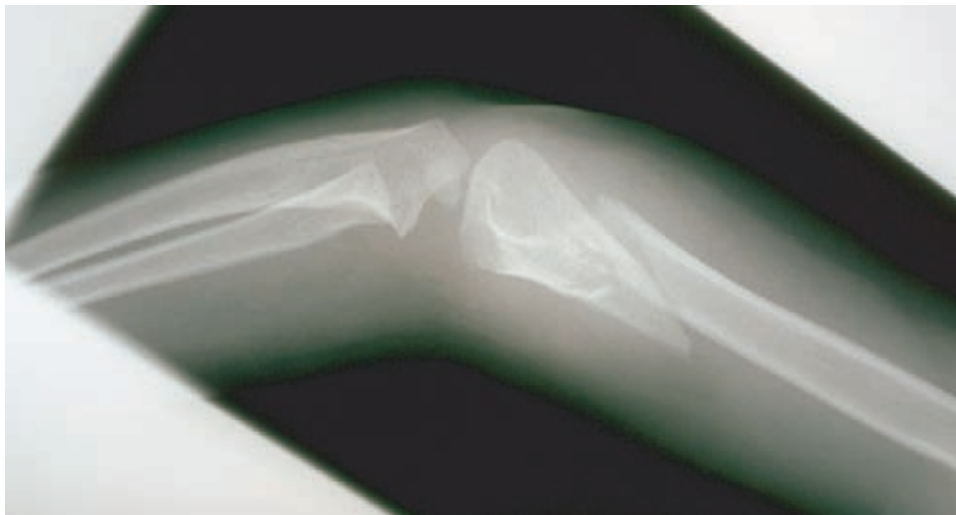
■ X-ray of an oblique fracture of the femur.
